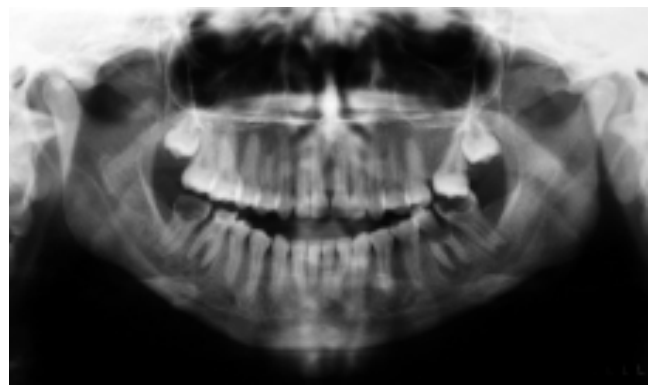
Panoramic radiographic image revealing discrete modification of the left mandibular condyle head.
